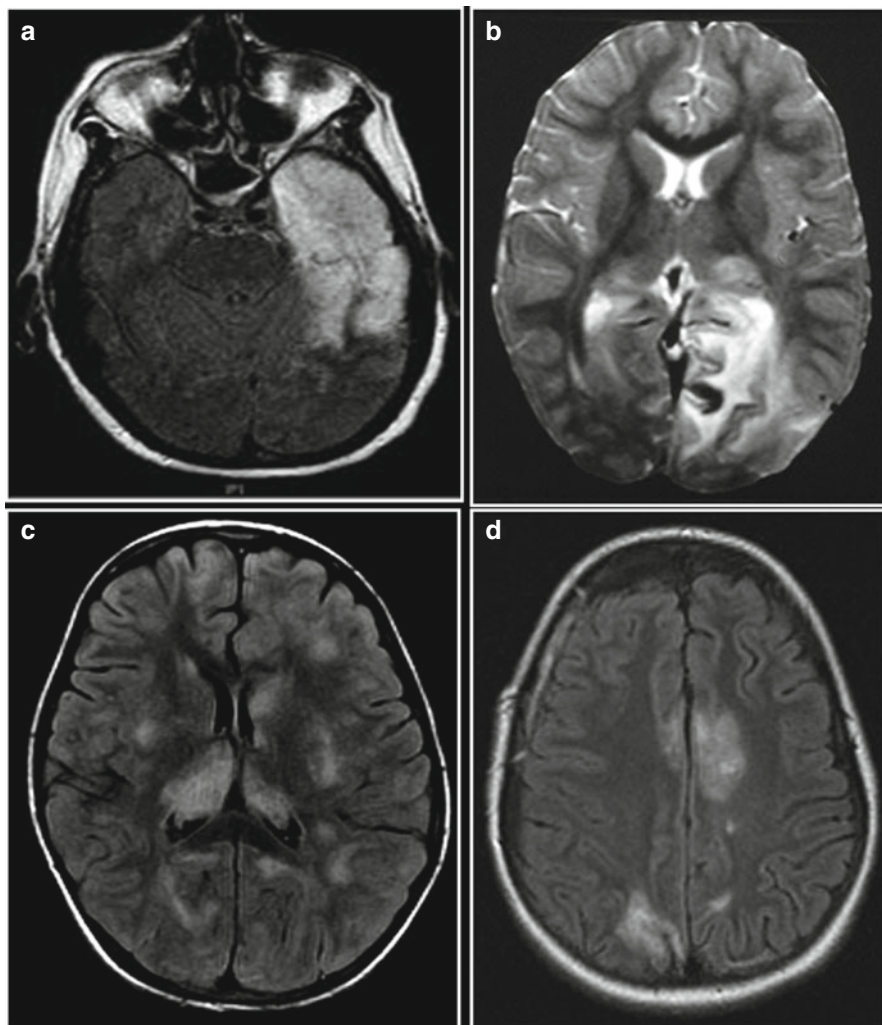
(a) Herpes simplex encephalitis: Axial FLAIR MRI showing severe hyperintensity affecting the left temporal cortex and subcortical white matter in a patient who presented with fever, seizures, and altered consciousness. (b) Herpes simplex encephalitis: T2-weighted MRI showing hyperintensity in the left parietal and occipital lobe, showing extra-temporal involvement can occur outside of the neonatal period. (c) Acute disseminated encephalomyelitis (ADEM): Axial FLAIR MRI showing multifocal, asymmetric hyperintense lesions affecting the subcortical and deep white matter, basal ganglia, and cortex in a patient who presented with altered consciousness, weakness, and ataxia whose course was consistent with ADEM. (d) Small vessel CNS vasculitis: Axial FLAIR MRI showing multifocal, asymmetric hyperintense lesions with prominent cortical and subcortical white matter hyperintense lesions in a patient who presented with headaches, weakness, and cognitive changes whose brain biopsy was consistent with small vessel CNS vasculitis
